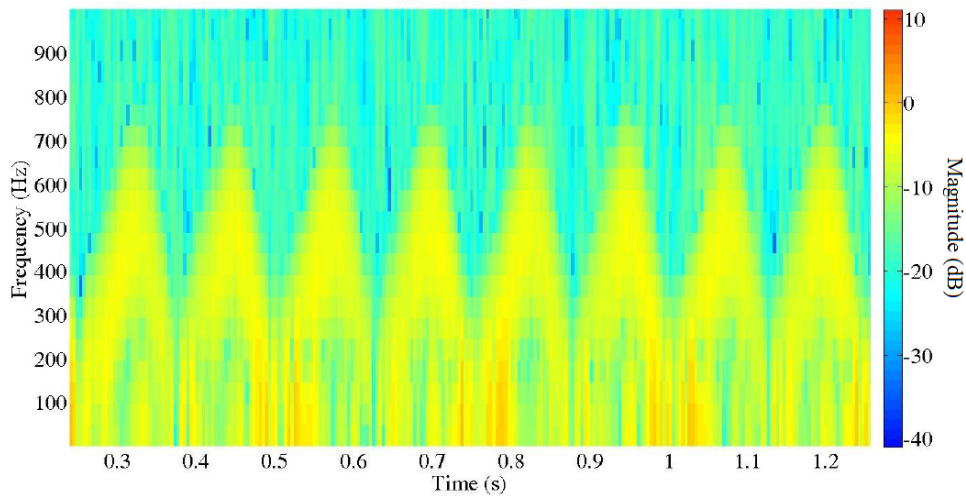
Detail of the Doppler spectrogram from the planar photodetector.
